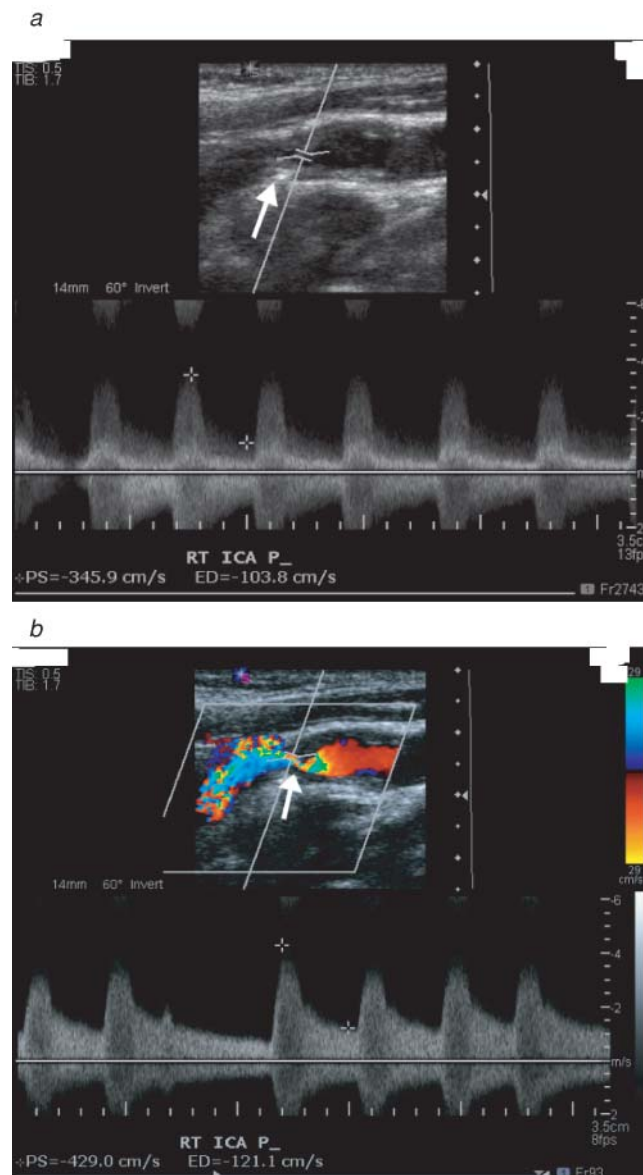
A 69-year-old male with a history of two transient ischemic attacks presented for investigation. (a) Duplex ultrasonography of both carotid arteries was performed. The longitudinal B-mode ultrasound demonstrates an eccentric echogenic plaque (arrow) within the right internal carotid artery (ICA) causing a marked stenosis. There is no evidence of shadowing and thus no significant calcification. Thus, this is consistent with a soft, lipid-rich plaque. (b) When the color Doppler is placed over the stenosis, there is marked luminal compromise (arrow). The peak systolic velocity is 429 cm/s. These findings are consistent with a significant greater than 70% stenosis. This patient went on to digital subtraction angiography and was treated with a carotid stent.
